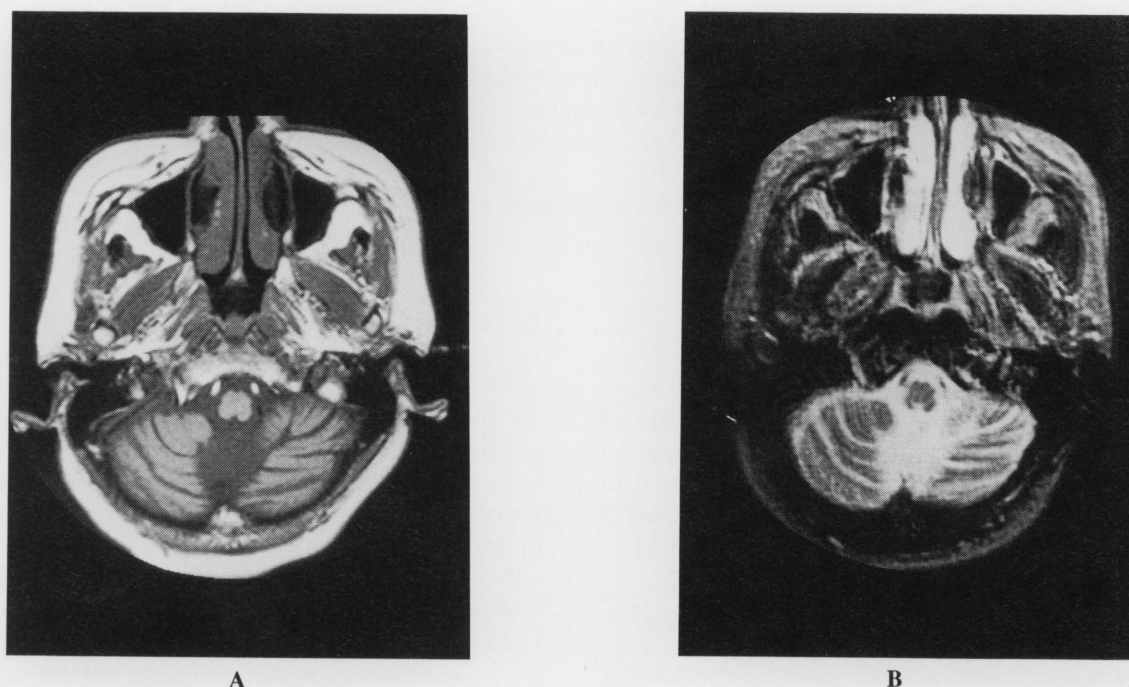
Magnetic resonance imaging T1 weighted image showing nasal mucosal thickening more than 5 mm (A) and T2 weighted image showing marked enhancement of nasal mucosa (B).
